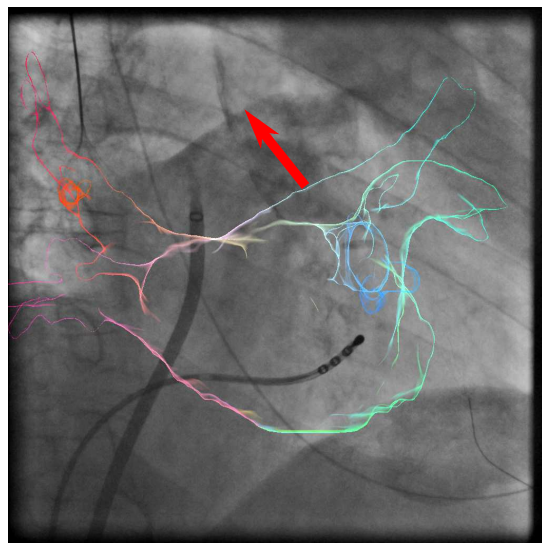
Registration of a 3-D model segmented from a preoperative MRI scan to fluoroscopic images. This can be accomplished by aligning the 3-D model to anatomical structures of the LA highlighted by contrast agent. This implies moving the model along the red arrow in this case.
